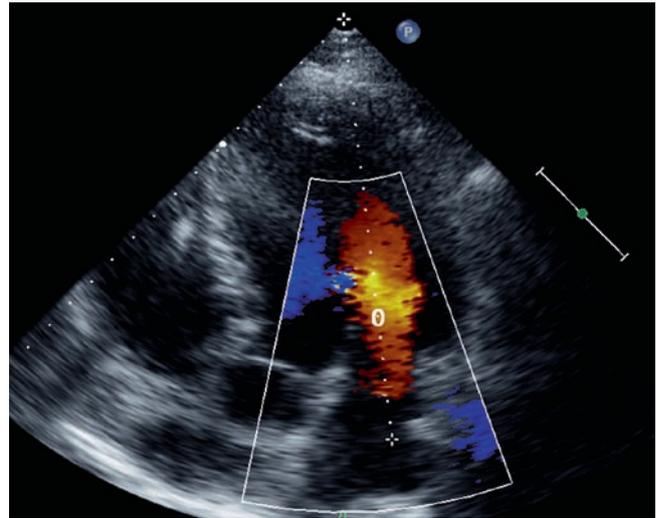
Placement of the sampling cursor parallel to the blood transmitral inflow (in apical 4-chamber view), guided by the transmitral colour Doppler imaging
